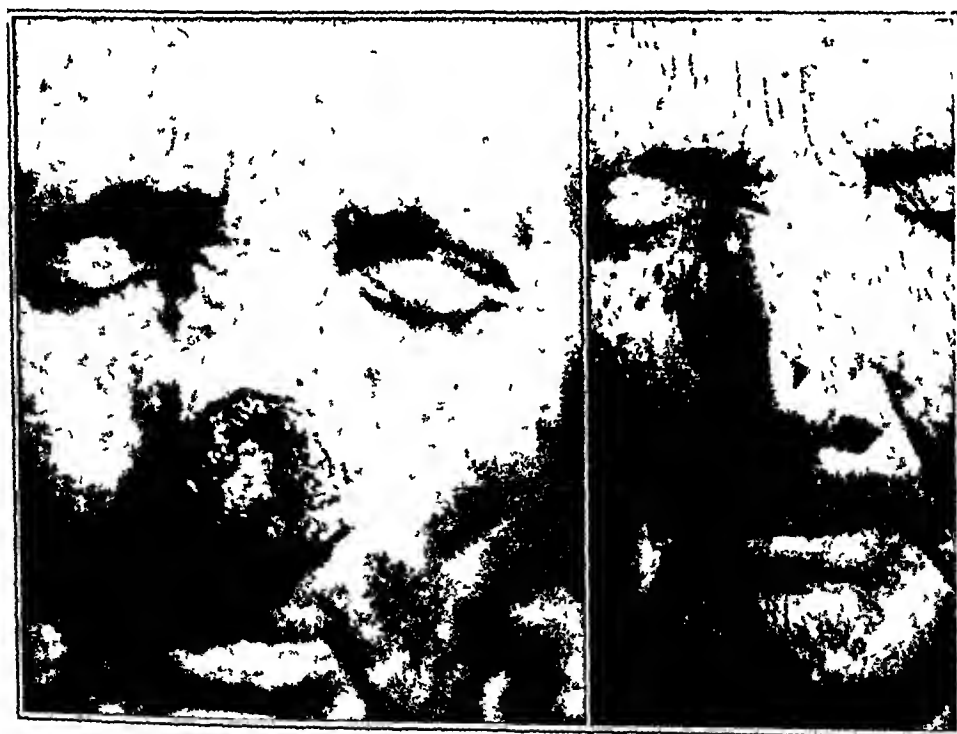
Prickle cell epithelioma of the nose. The lesion had received an unknown quantity (twelve treatments) of roentgen radiation one year previously. Nine needles containing 1 mg of radium were implanted at the base of the growth for one hundred and ten hours. The total dose was 990 milligram hours. The second photograph was made four months later.
